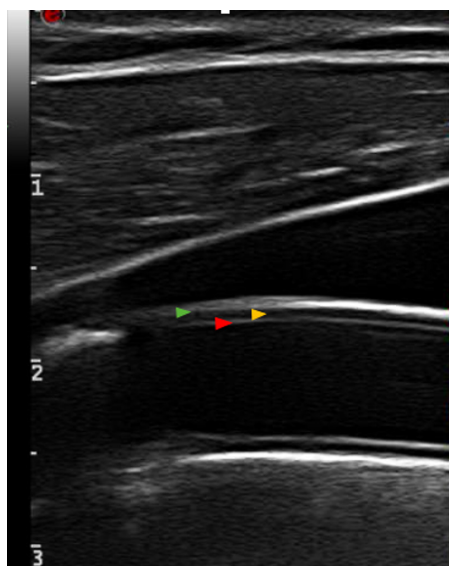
Nonpathologic axillary artery ultrasound. Longitudinal normal section. Pulse repetition frequency at 2.5. The intima (red arrowhead), media (yellow arrowhead), and adventitia (green arrowhead) can be visualized.
